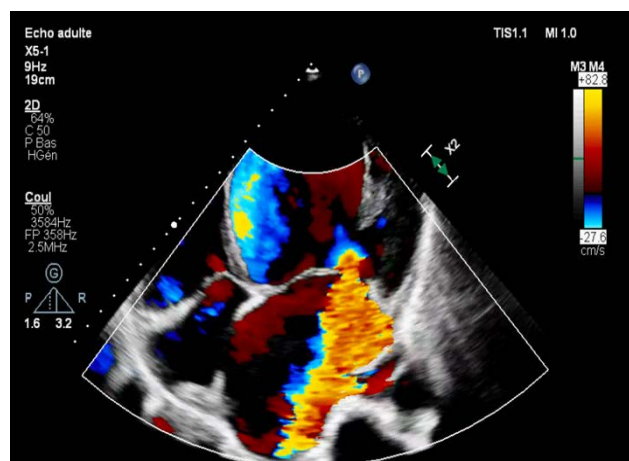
Apical four-chamber color Doppler view of torrential mitral regurgitation. Apical four-chamber view demonstrating a massive holosystolic mitral regurgitant jet extending deep into the pulmonary veins, consistent with severely elevated left-atrial pressures
